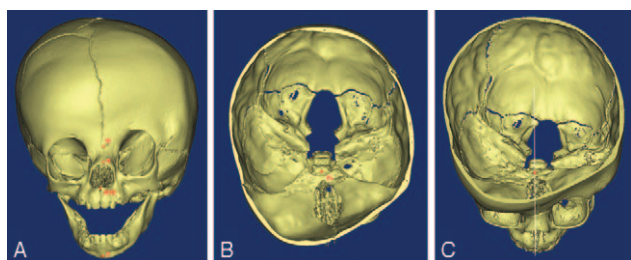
Bony landmarks for computed tomography-based cephalometric analysis. (A) Anteroposterior view. (B) Skull base. (C) Lateral view.
